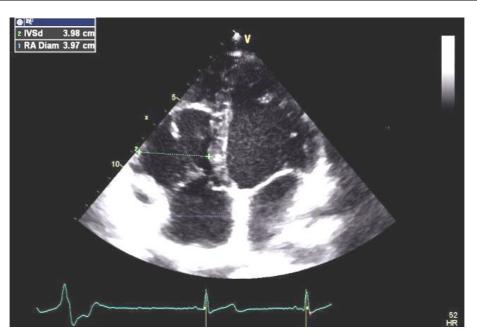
Transthoracic echocardiography:* in apical four chambers section indicates a dilated right heart with right ventricle with a diameter of about 40 mm.
